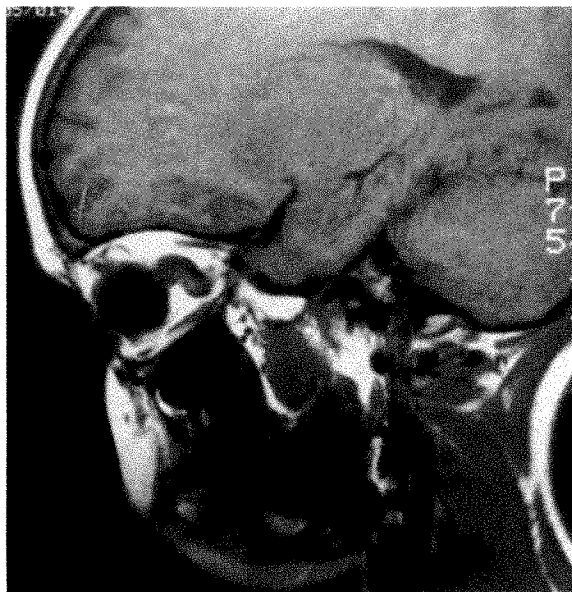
(Imes and Hoyt). Case 2. T₁-weighted sagittal magnetic resonance images of the left orbit. The optic nerve is tubularly thickened, elongated, and bent sharply downward in the midorbit.
